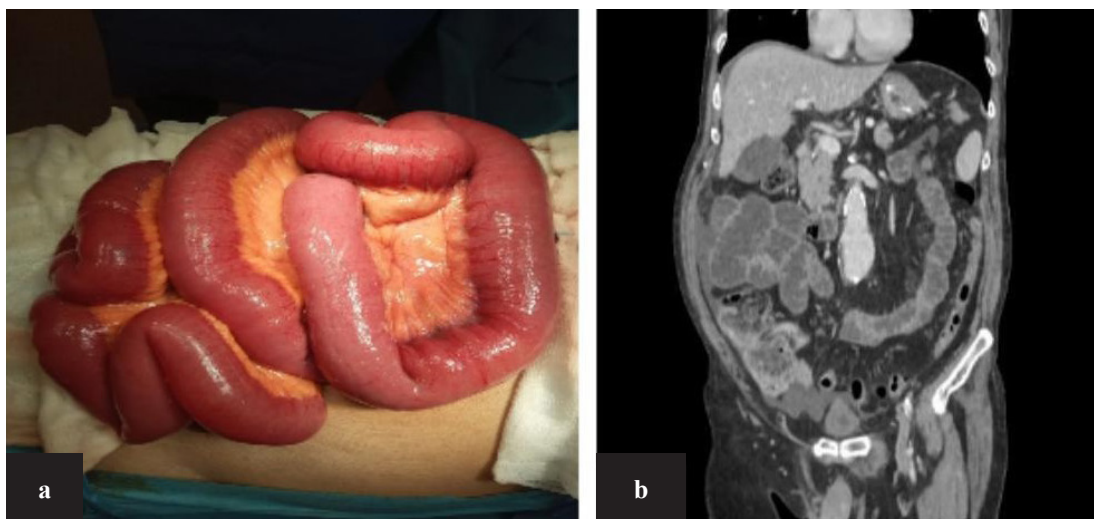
2a. Intraoperative image of the bowel with no signs of ischemia or other pathology; 2b. Postoperative follow-up abdominal CT with regression of intramural and portal venous system air
